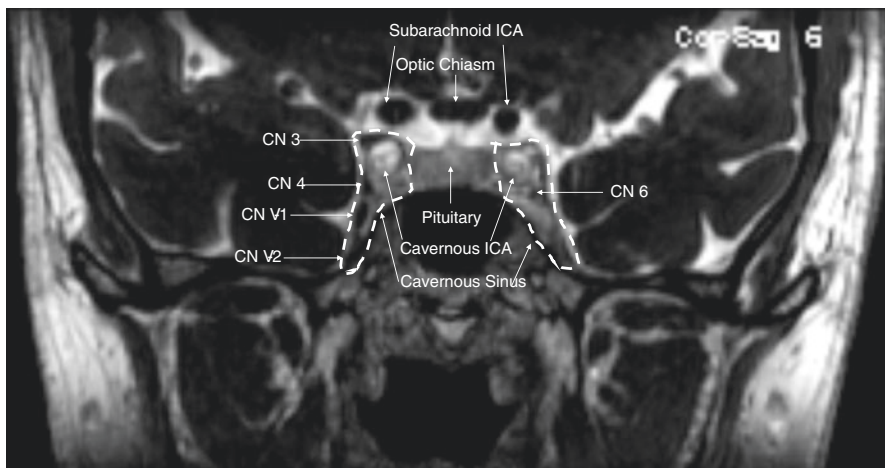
Cavernous sinus. Coronal CISS MRI shows the structures of the cavernous sinuses (outlined by the dotted lines). CNs III, IV, V1, and V2 are protected within the dural wall of the cavernous sinus, whereas CN VI is located more medially within the cavernous sinus. (© AR Carey 2020. All Rights Reserved)
